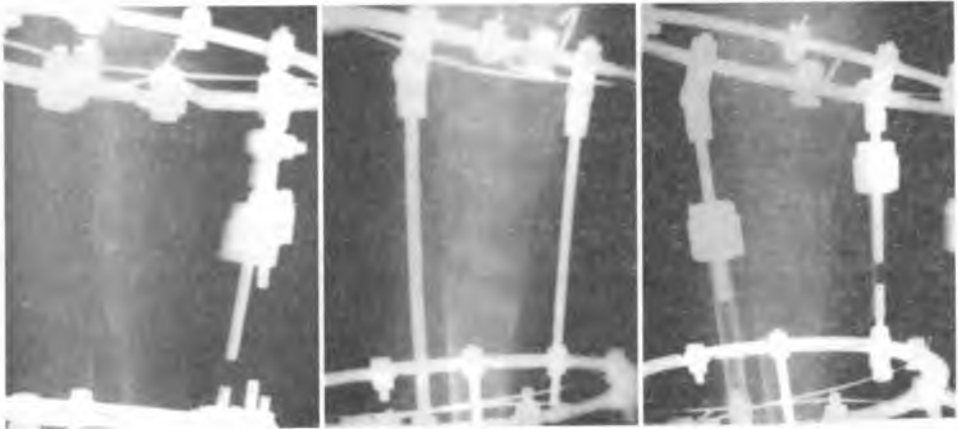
Radiographs of the right femur of 14 years old boy. Before the first application of PRP (A), 3 weeks later after (B), and 7 weeks after application of PRP (C). Callus formation was satisfactory during the lengthening period
